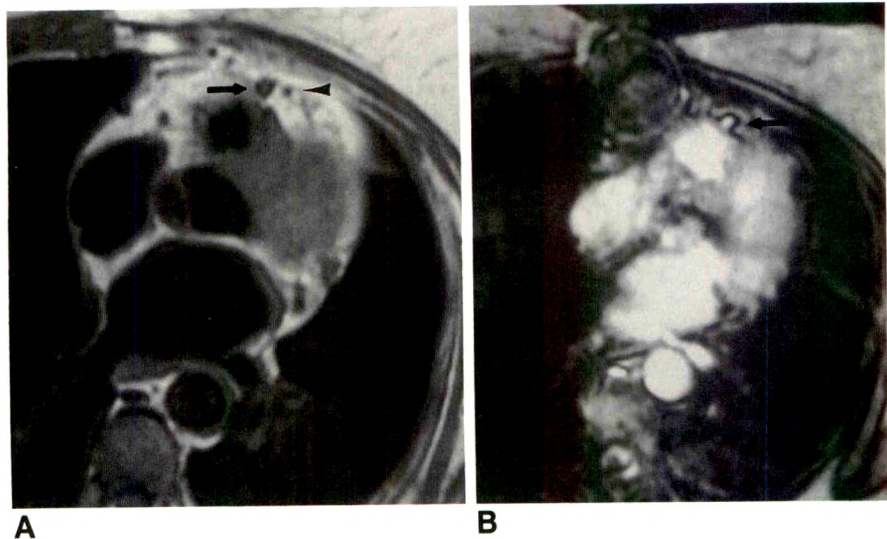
A, Spin-echo image of an angiographically proved patent saphenous vein bypass graft to left anterior descending (LAD) coronary artery. A signal void of flowing blood is seen within graft, indicating its patency (arrow). That graft appears patent in segment imaged does not necessarily imply that distal graft is open. Arrowhead denotes native LAD coronary artery. B, Cine MR image of same patent saphenous vein bypass graft shows high signal intensity in heart chambers and in bypass graft (arrow).
